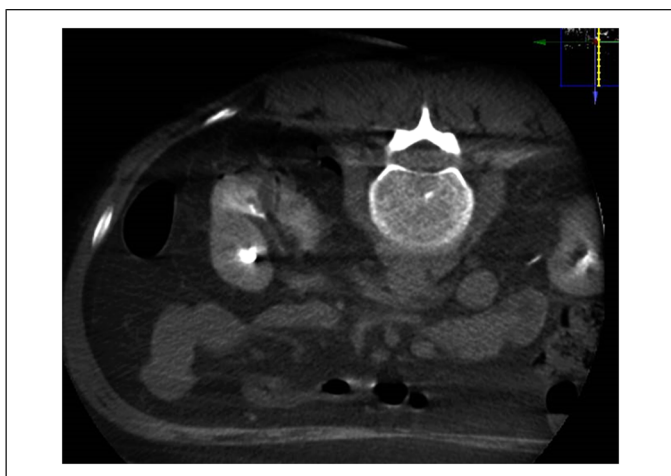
Final unenhanced CBCT acquired to assess the absence of immediate complications.
